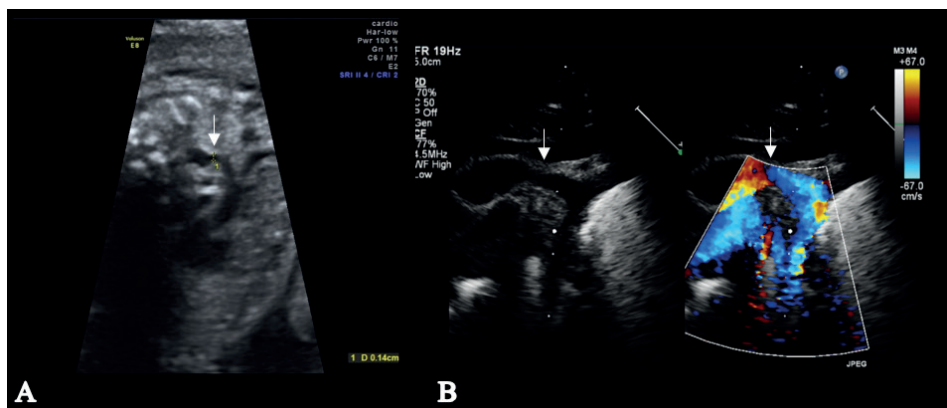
Ultrasound image of case 2. A: 28 weeks' gestation, B: after birth. Arrows indicate the coarcted segment
